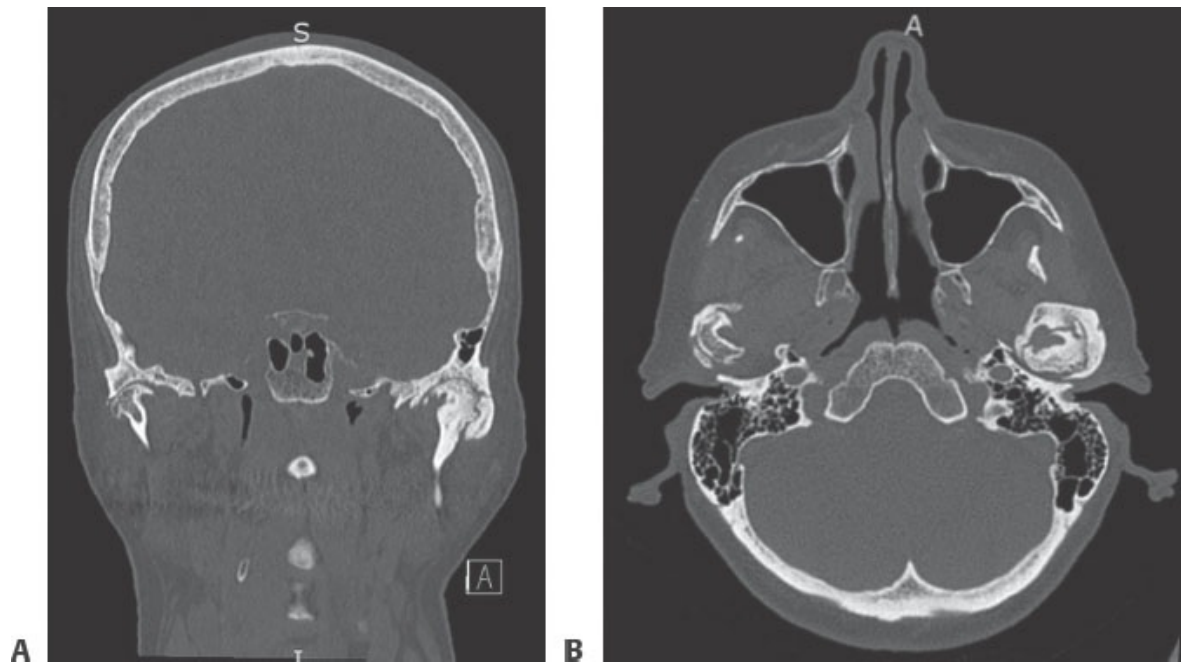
• Coronal (A) and axial (B) computed tomography views of a patient with left-sided temporomandibular joint ankylosis.
